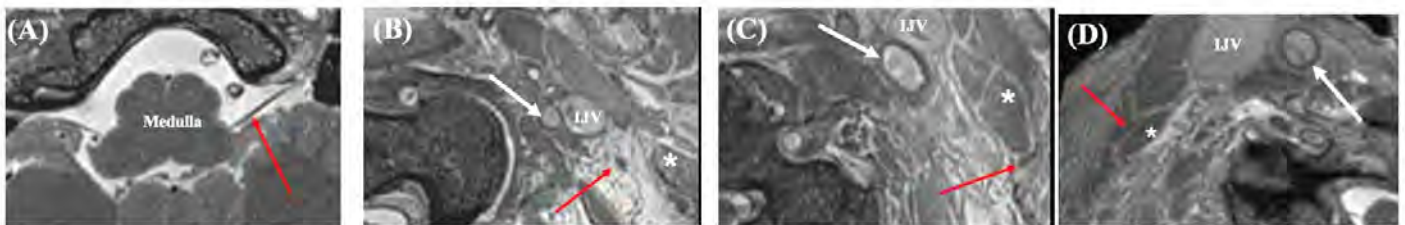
(A) Axially reformatted 0.5mm CISS MRI of the cisternal segment of left CN X-XI complex (red arrow) as it originates from the posterolateral sulcus of medulla oblongata; (B) Axially reformatted 0.5mm CISS MRI of left CN XI in the anterior triangle segment as it travels laterally in the neck to supply the sternocleidomastoid muscle (\*); (C) Axially reformatted 0.5mm CISS MRI of the intramuscular segment of left CN XI as it emerges after piercing the sternocleidomastoid muscle; common carotid artery (white arrow); (D) Axially reformatted 0.5mm CISS MRI of the intramuscular segment of right CN XI as it pierces the sternocleidomastoid muscle;
